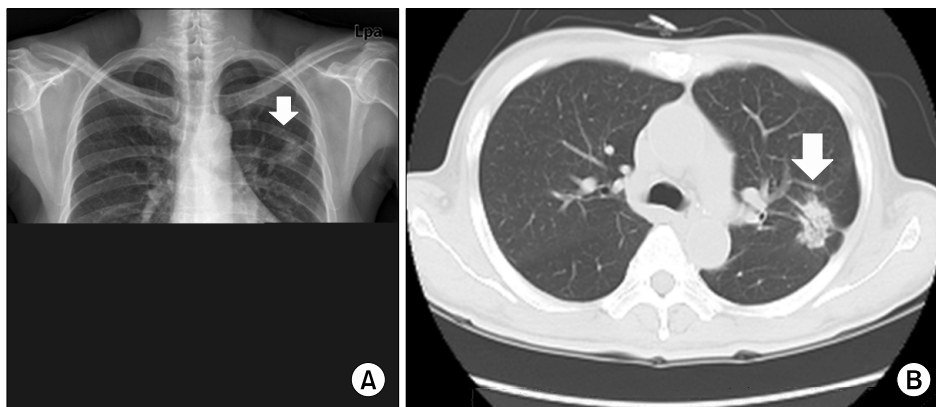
(A) Chest X-ray showed an ill-defined nodule in left upper lobe (white arrow). (B) Chest computed tomography showed an irregular mass with marginal spiculations in apicoposterior segment of left upper lobe (white arrow).
